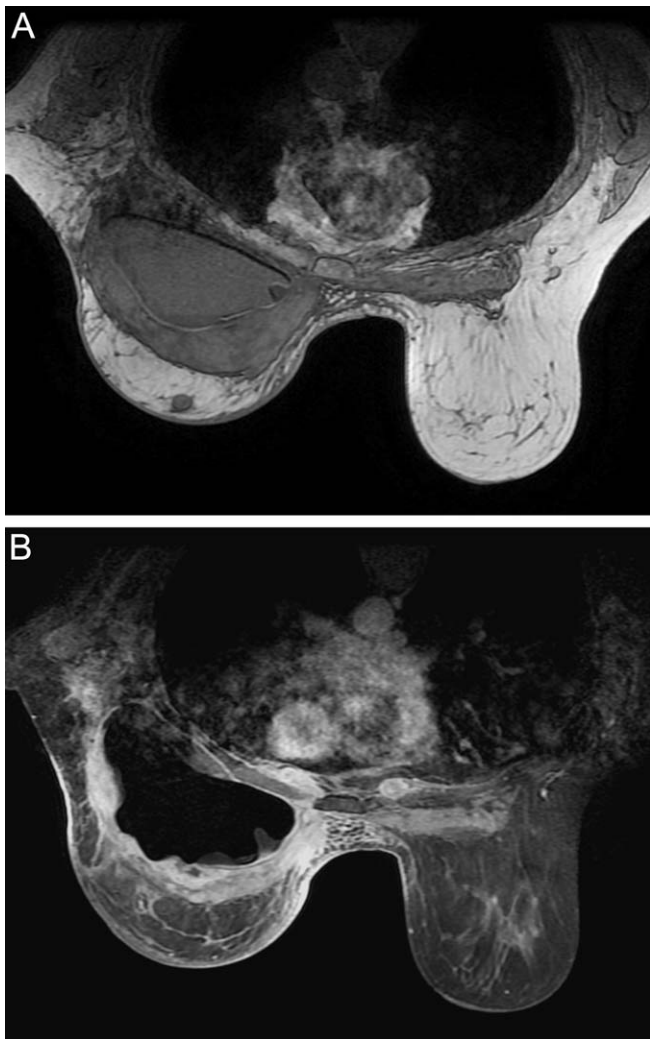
Magnetic resonance (MR) images of a breast implant-associated anaplastic large cell lymphoma (Table, patient No. 45). Axial precontrast T1-weighted (A) and fat-suppressed T2-weighted (B) MR images demonstrate an enhancing mass completely surrounding the breast implant. The mass infiltrated the chest wall, abutting the pleura medially.
